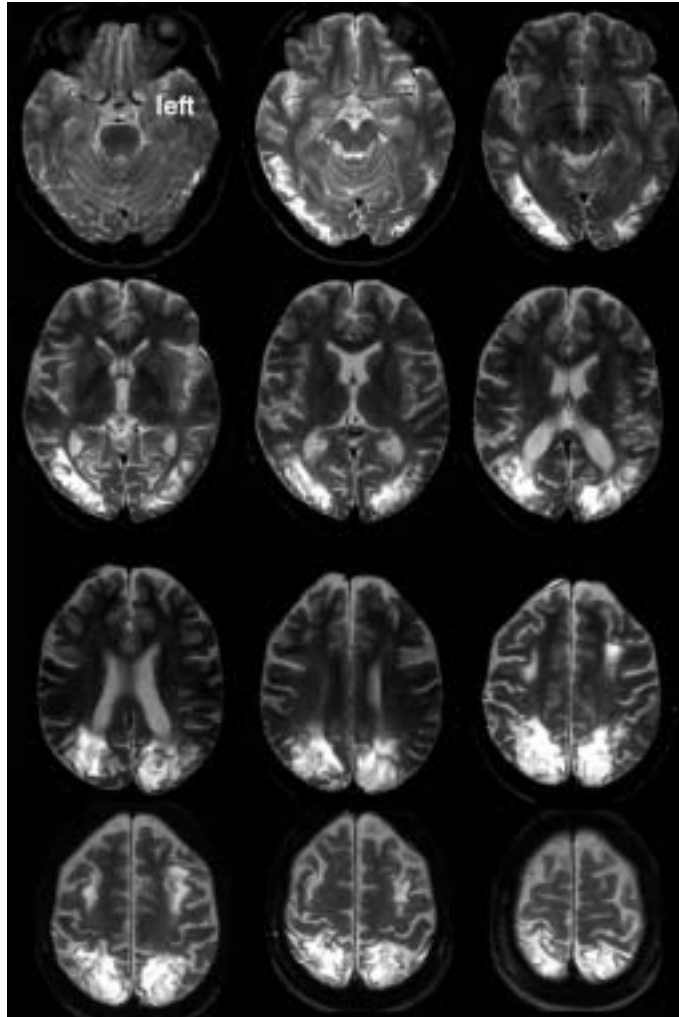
The MRI horizontal sections show AT's symmetric occipito-parietal lesions (see description in text).
